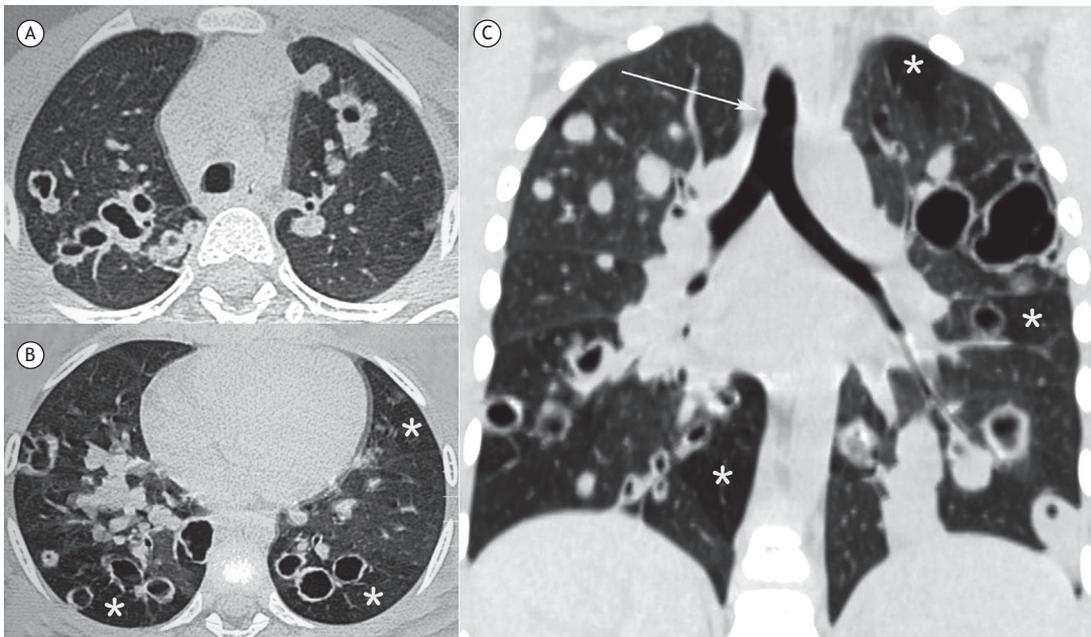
Male patient, 6 years old. Axial CT scans at the level of the upper (in A) and lower lobes (in B), as well as a coronal CT scan of the lungs (in C), showing nodulation in the trachea (white arrow), sparse areas of air trapping in both lungs (white asterisks), and bilateral parenchymal nodules of varying sizes (some solid or cavitated) disseminated in the lungs.
